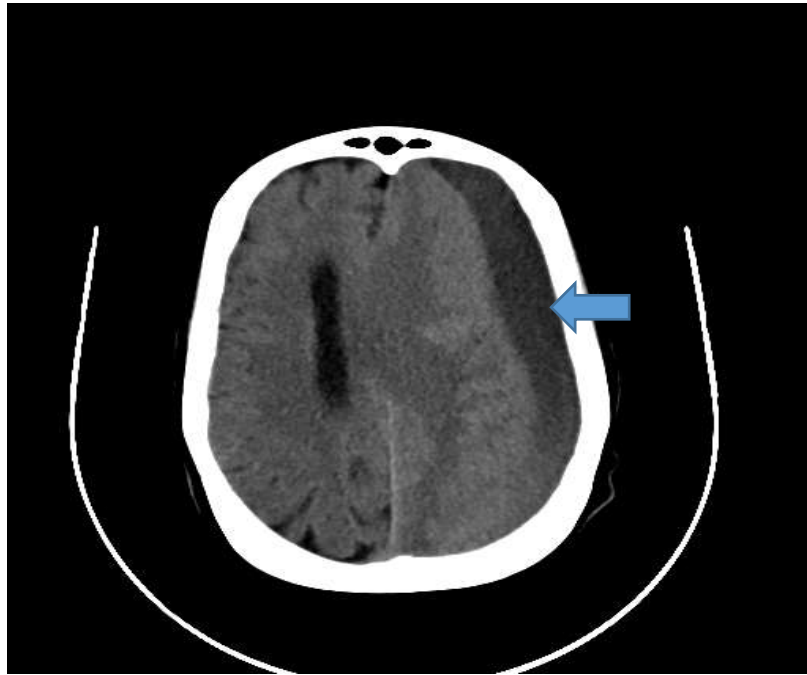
Brain window, NE axial CT of a 77 year old female who presented with chronic headache confusion and diminished memory. CT showed left frontoparietotemporal crescent shaped hypodense lesion with significantly associated mass effect in keeping with chronic subdural haematoma.
